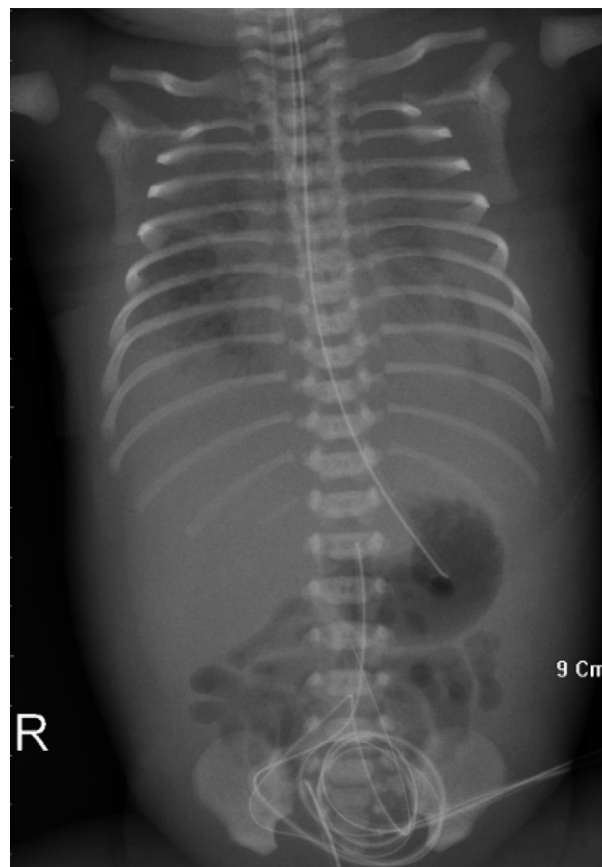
X-ray picture showing the presence of bilateral large amounts of pleural effusion, ascites (centralized bowel loops), and subcutaneous edema.
